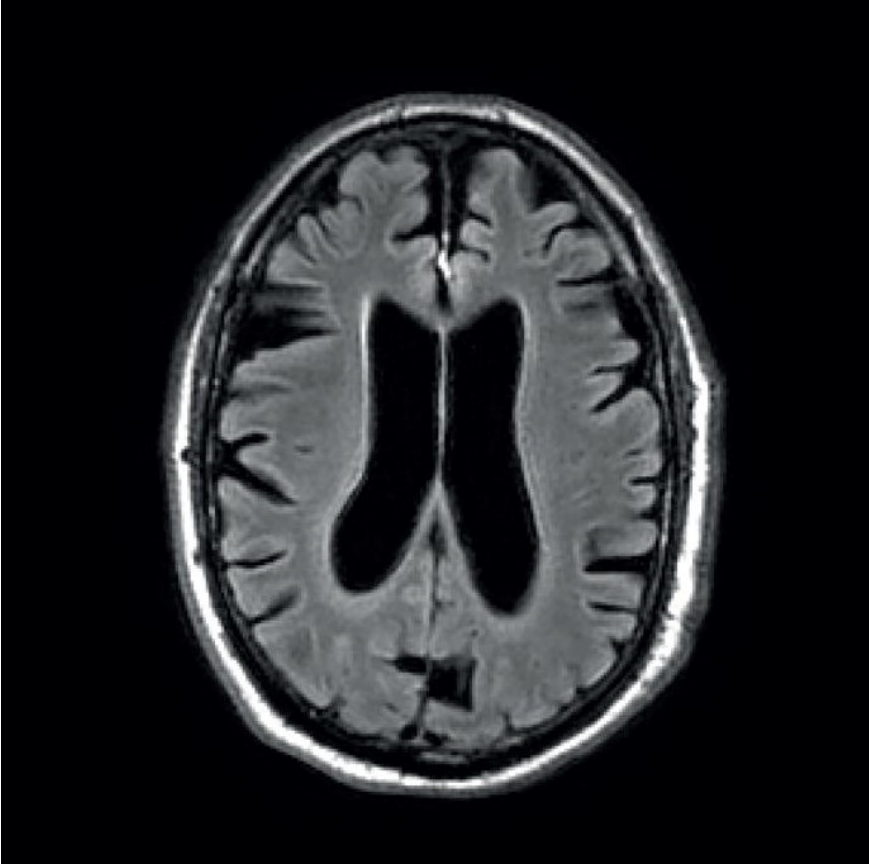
Transaxial MRI fluid-attenuated inversion recovery image showing global atrophy and enlarged ventricles in a Parkinson's disease with dementia subject[21].
